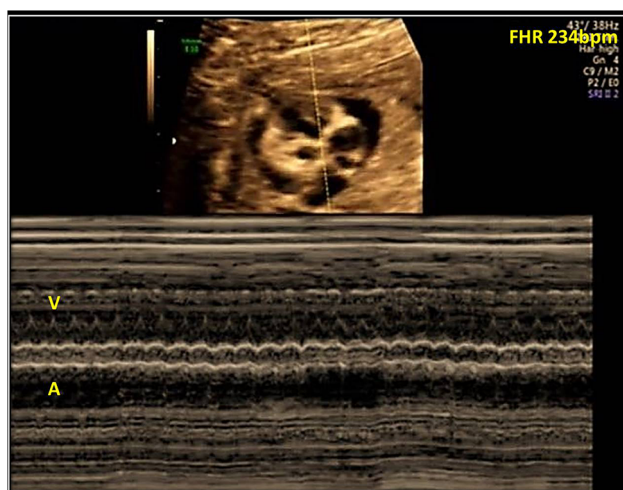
Spectral Doppler image for case no. 8 showing echogenicic endo-myocardium, mild pericardial effusion and tachycardia (FHR 234 bpm) with 1:1 AV conduction
